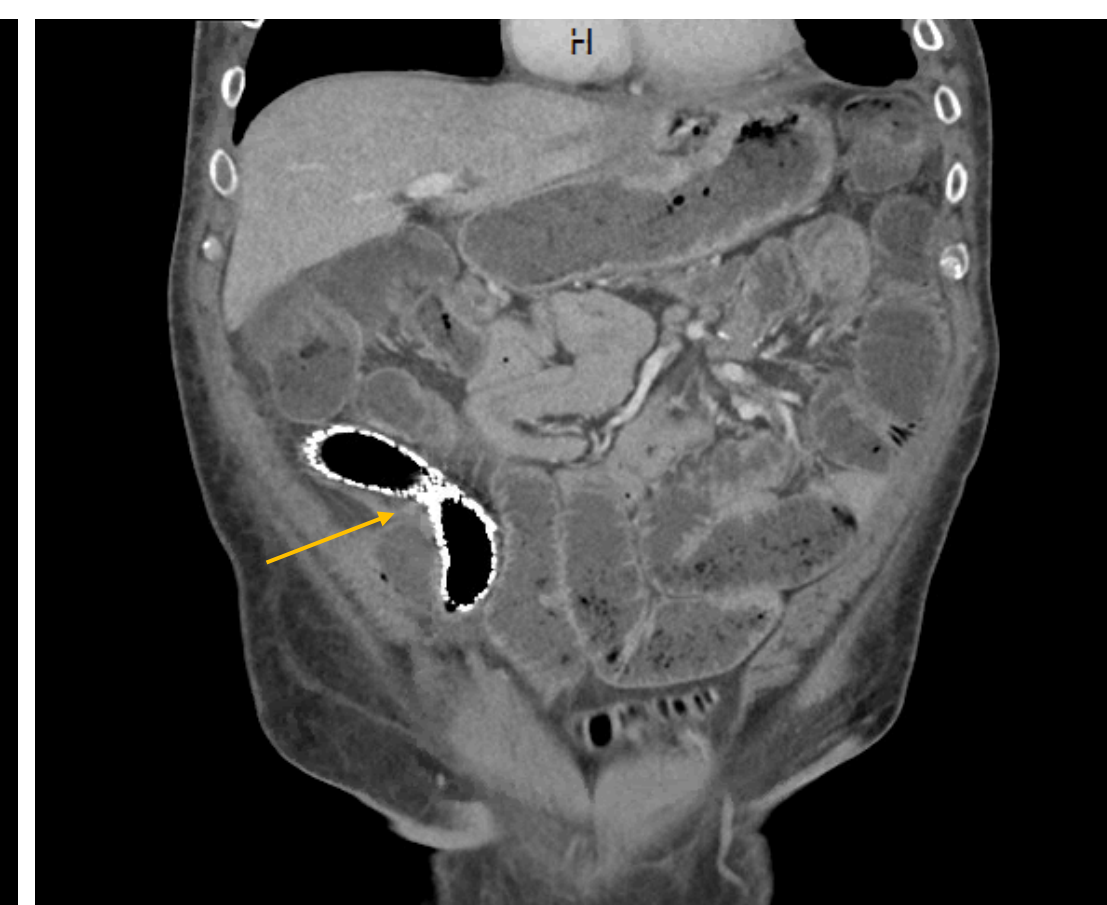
CT abdomen and pelvis with IV contrast (7/23/2022). Arrow indicates migrated stent.
